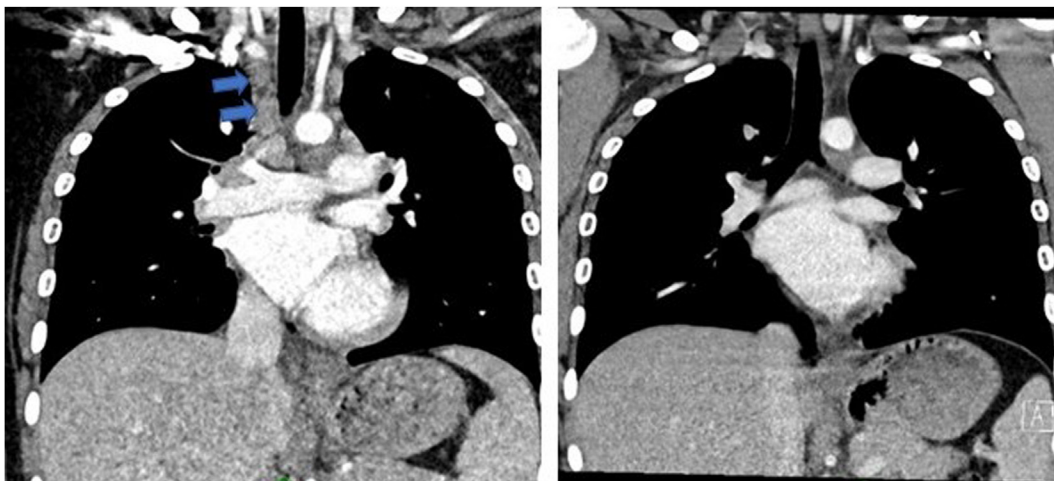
A chest computed tomography image (*left*) demonstrating perihilar lymphadenopathy (*blue arrows*) improved significantly (*right*) after discontinuation of dupilumab therapy.
